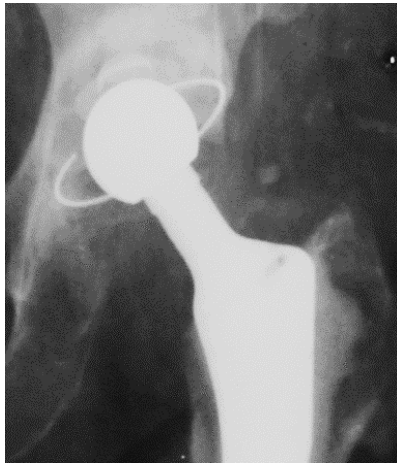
Left hip X-ray showing 1st degree heterotopic ossification.*
